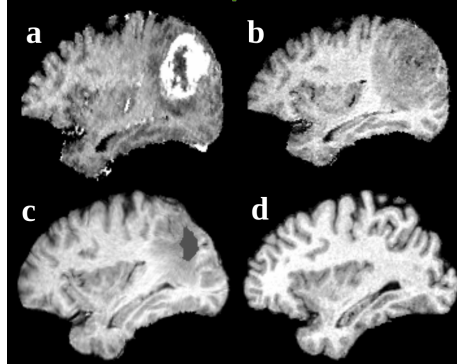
Spatial normalization example using ORBIT. The top row shows the T1-weighted patient's image (a) with and (b) without contrast-enhancement rigidly registered to the atlas in (d). The image in (b) after deformable registration to the normal atlas is shown in (c). The initial tumor seed representing tissue death is shown with gray color in (c) and indicates the location of initial tumor appearance, as defined in the atlas. The surrounding peri-tumor edema or infiltration, as mapped in the normal atlas, is also visible.
